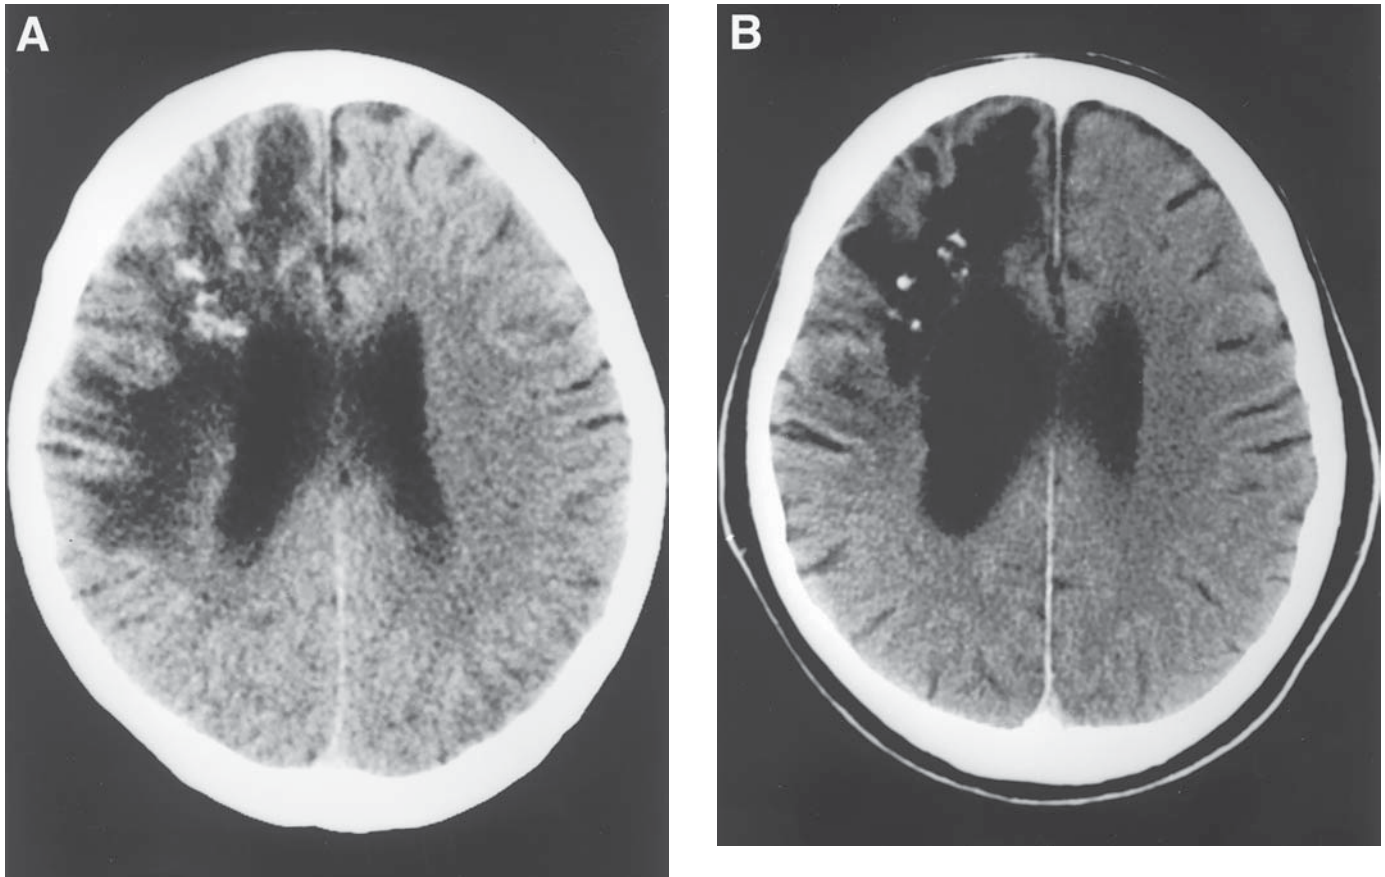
Axial CT scan in a 42-yr-old man treated with external beam conventional RT for a right frontal anaplastic astrocytoma. (A) Radionecrosis focus appearing as an enhancing lesion in the tumor bed 1 yr after RT. (B) Isolated calcifications 4 yr later.
